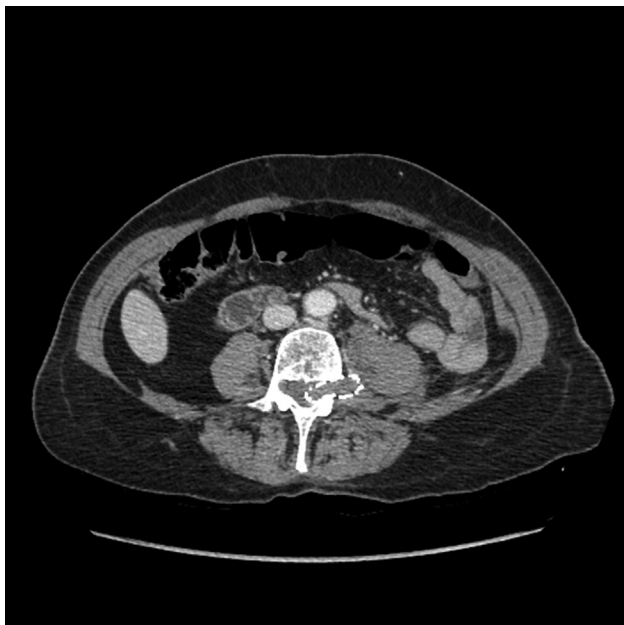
Computed tomography after angioplasty showing the stent passing through the foramen of L4 – L5.
